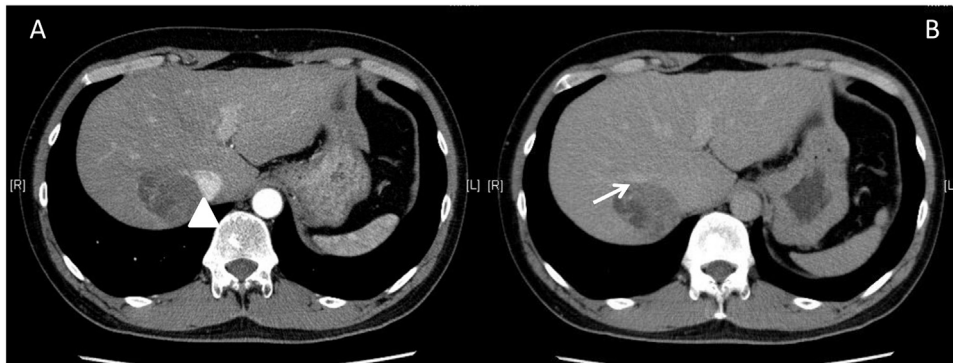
Dynamic contrast-enhanced CT image showing an approximately 5-cm, well-circumscribed tumor adjacent to the IVC (arrowhead in A) and the RHV (arrow in B) in segment 7. A) Heterogeneous enhancement was visible during the arterial to portal phase of the CT examination. B) The heterogeneous enhancement persisted until the equilibrium phase.
